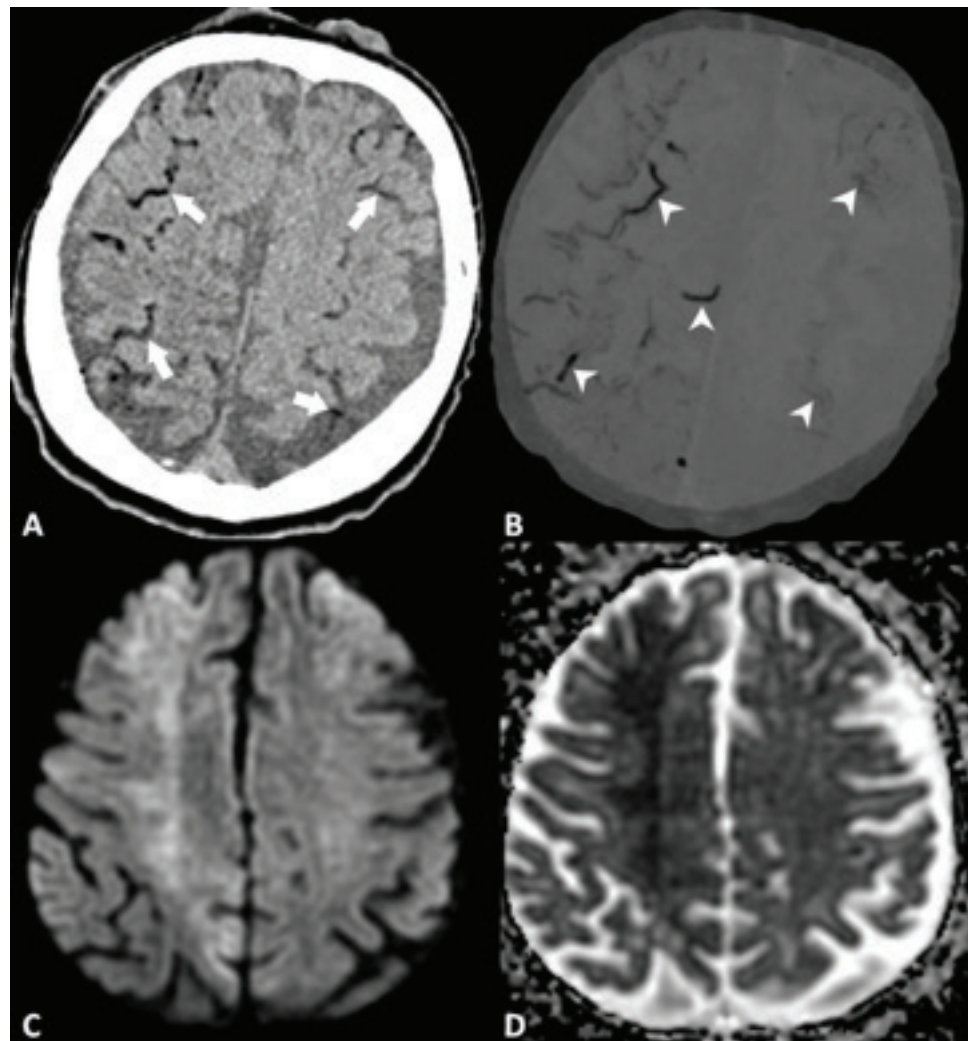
Imaging findings of a 75-year-old male patient with sudden onset of decreased consciousness. A. Non-contrast CT scan showed air densities along the vascular trace in the frontoparietal sulci of both cerebral hemispheres (white arrows). B. Minimum intensity projection reformation from CT showed air images probably of arterial origin more clearly (white arrowheads). C and D. Diffusion-weighted imaging showed restricted diffusion in bilateral cerebral hemispheres consistent with watershed infarction.
